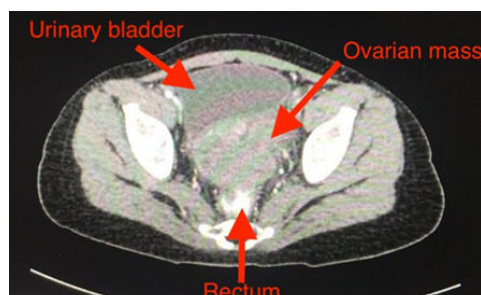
Abdomino-pelvic computed tomography showing a well-defined heterogeneous non-enhancing lobulated pelvic mass between the uterus and rectum.
